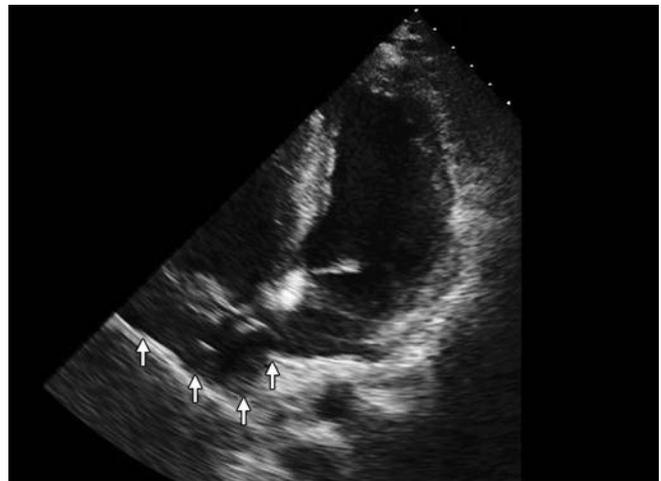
Transthoracic 4-chamber view with focus on the mitral valve.
